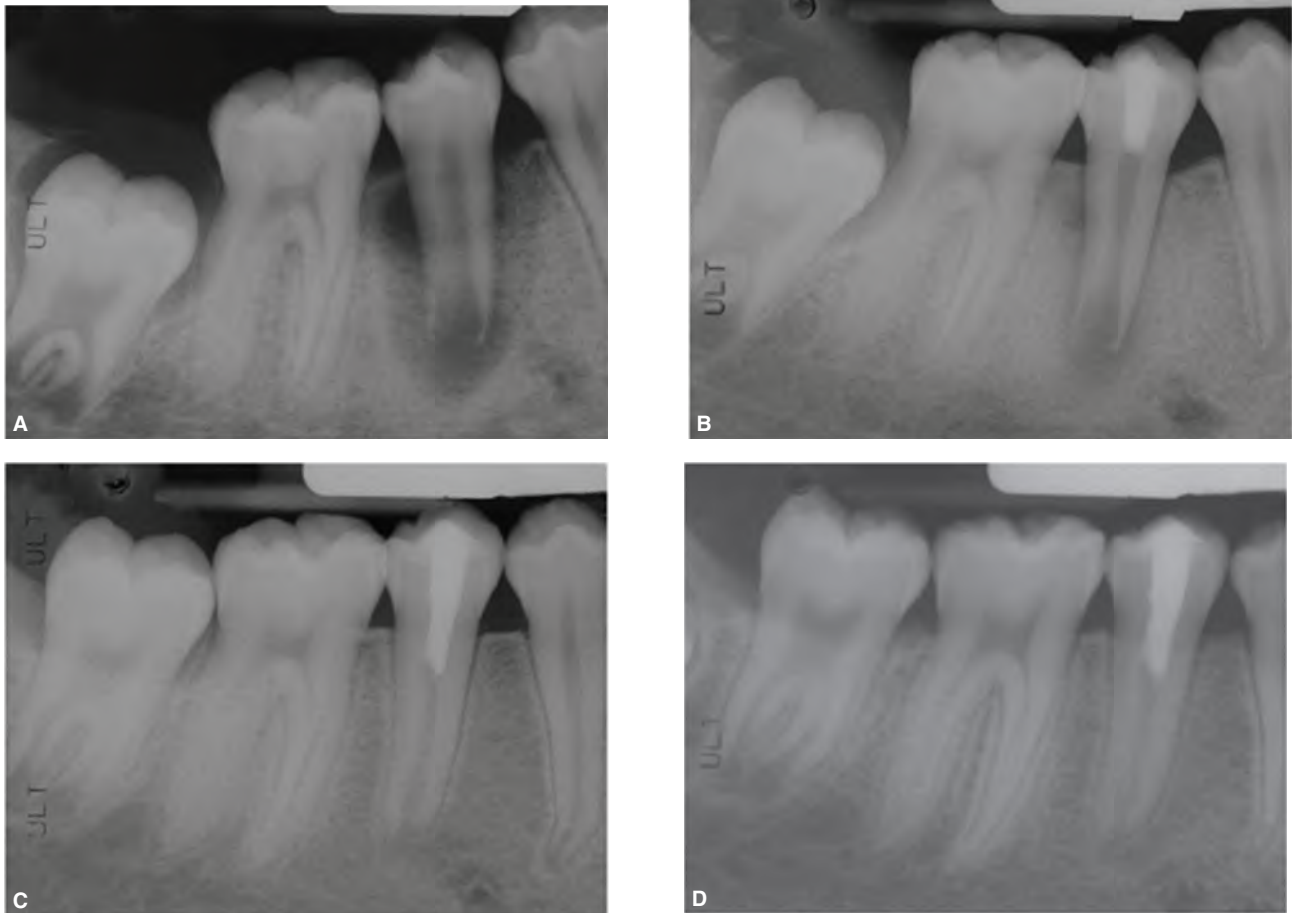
An 11-year-old male patient was diagnosed with pulpal necrosis and chronic apical abscess in the mandibular second premolar. The tooth was treated with a regenerative endodontic procedure (revascularization) using triple antibiotic paste (minocycline, ciprofloxacin and metronidazole) as intracanal medicament. A. Preoperative radiograph shows large periradicular radiolucency and immature root with open apex. B. Post-operative radiograph taken 26 months after treatment showing signs of healing; C. 12-month follow-up showing complete resolution of radiolucency and continued root development. D. 18-month follow-up showing further root development. The patient remained asymptomatic during the follow-up period and the tooth responded to both electric and cold sensitivity tests. (Adapted with permission from Banchs and Trope.¹⁴⁸)
